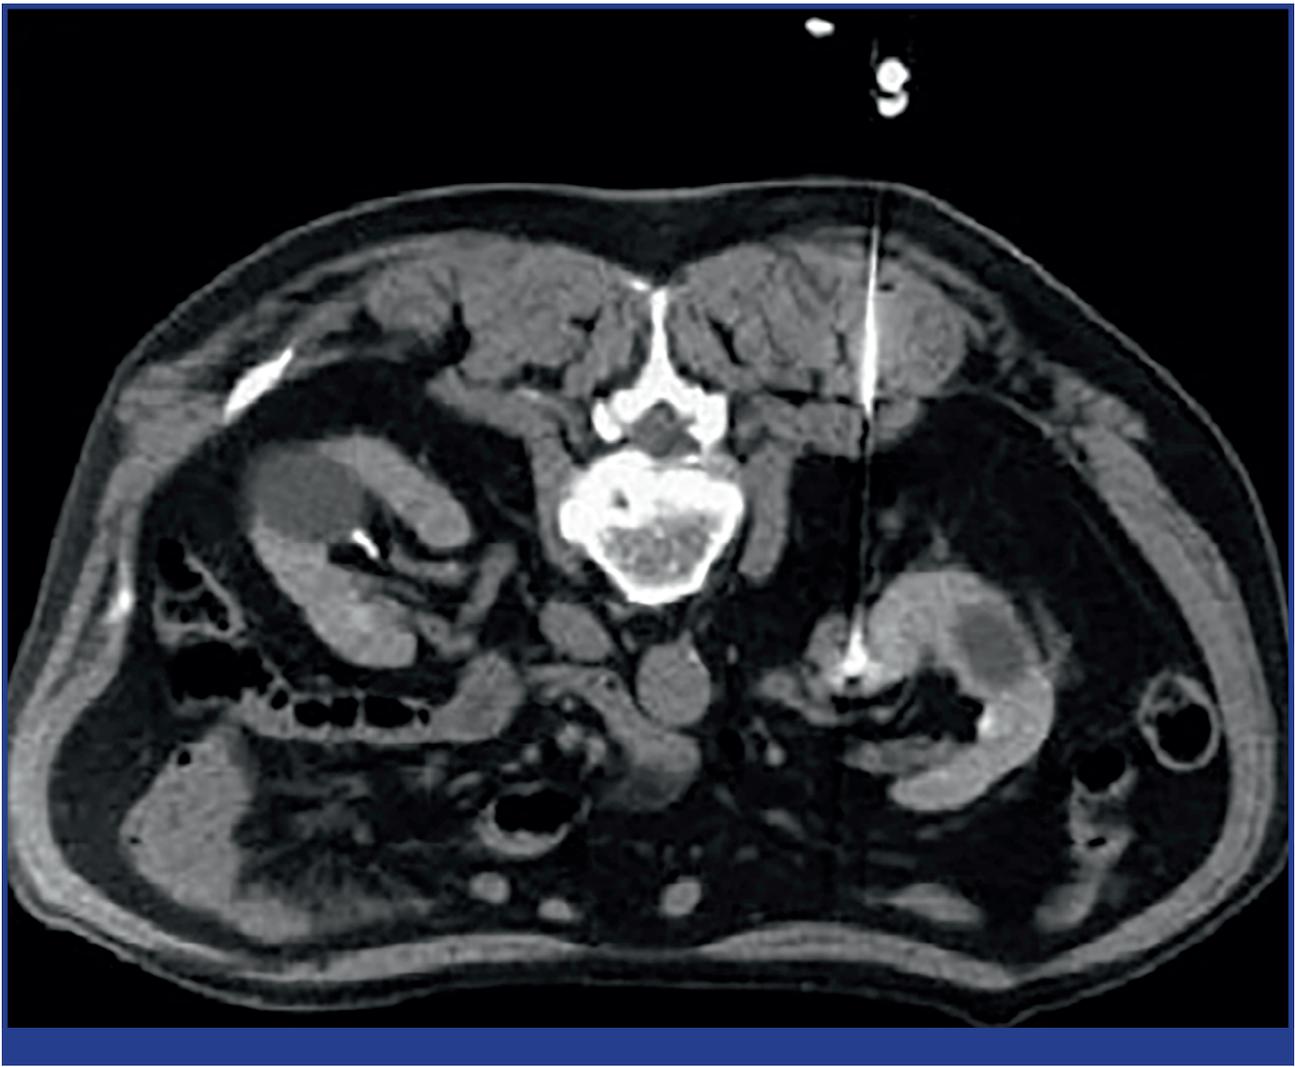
The radiofrequency probe is placed percutaneously under CT scan guidance at the margin of the renal tumour.
